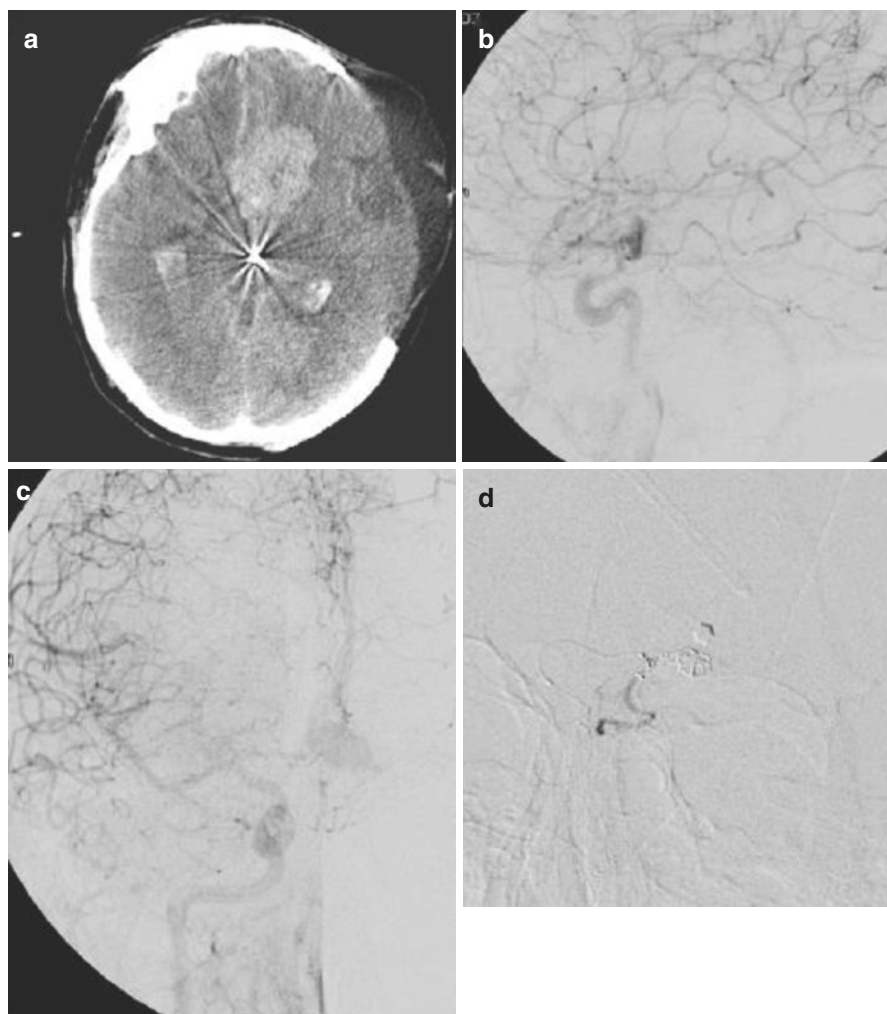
(a) CT showing delayed hematoma in patient involved in a shrapnel injury to base of skull and orbit. (b) Lateral and (c) AP angiogram revealing pseudoaneurysm of anterior cerebral artery. (d) Pseudoaneurysm was treated by endovascular coiling. The patient's initial angiogram after injury was negative
